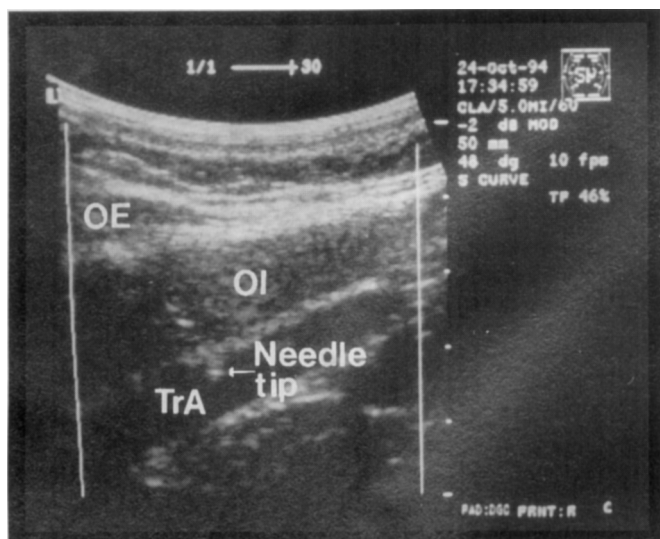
Transverse ultrasound image of the abdominal wall just distal to the rib cage showing the transversus abdominis muscle (TrA), the obliquus internus abdominis muscle (OI), and the obliquus externus abdominis muscle (OE). Note the high-contrast oblique echo of the needle with the needle tip located in the muscle belly of the TrA. The origin of the needle is not observable in this image. The white lines on either side of the image are indicators of image intensity.
